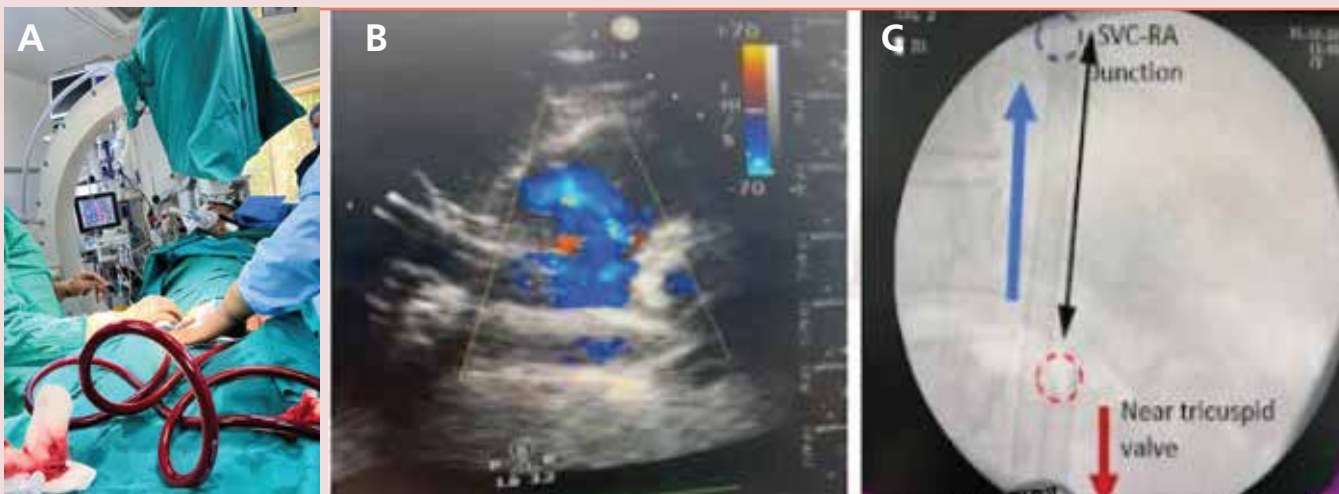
3b. 3c. Venovenous ECMO inserted in 45 degree head up position with ultrasound ECHO and C arm guidance
